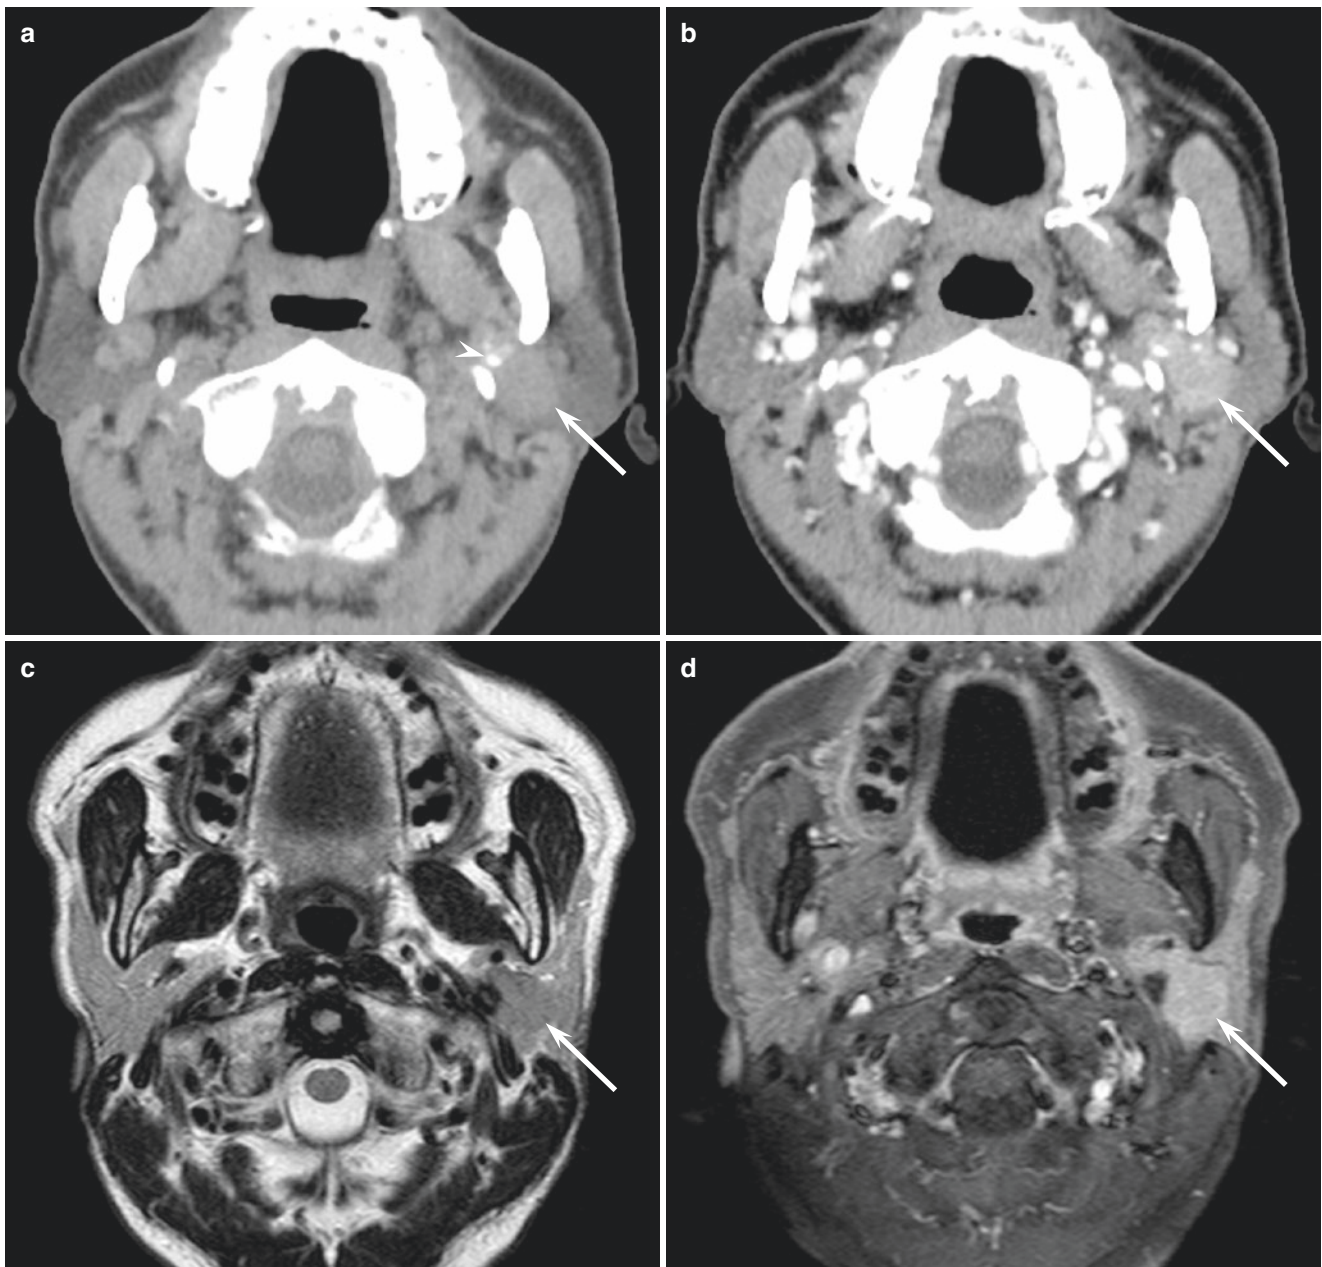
A 71-year-old man with salivary duct carcinoma of the left parotid gland. (a) Unenhanced CT image shows an ill-defined lesion (arrow) with calcification (arrow head). (b) Contrast-enhanced CT image shows a homogeneously enhanced lesion (arrow). (c)
